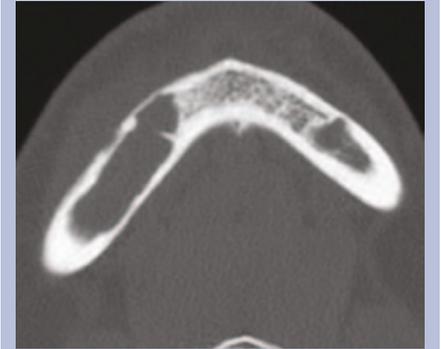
Spiral axial CT scan at the level of the mandibular lesion, revealing the mandibular cavity and thinning of the buccal and lingual cortical plates.
